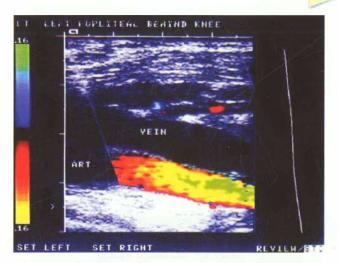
Colour Doppler showing femoral artery and vein
